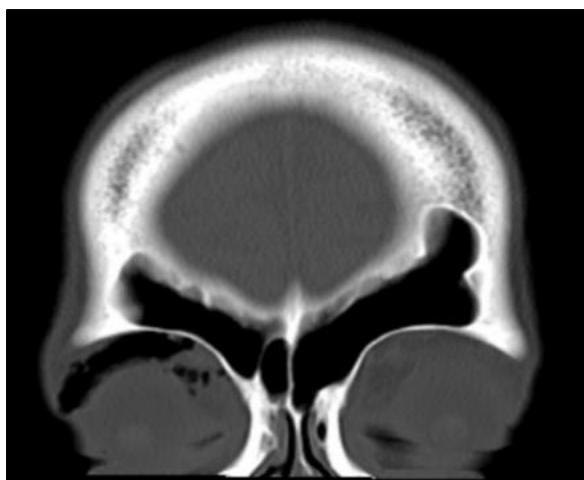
Coronal view of the CT bone window showing trapped air in the right orbit.
